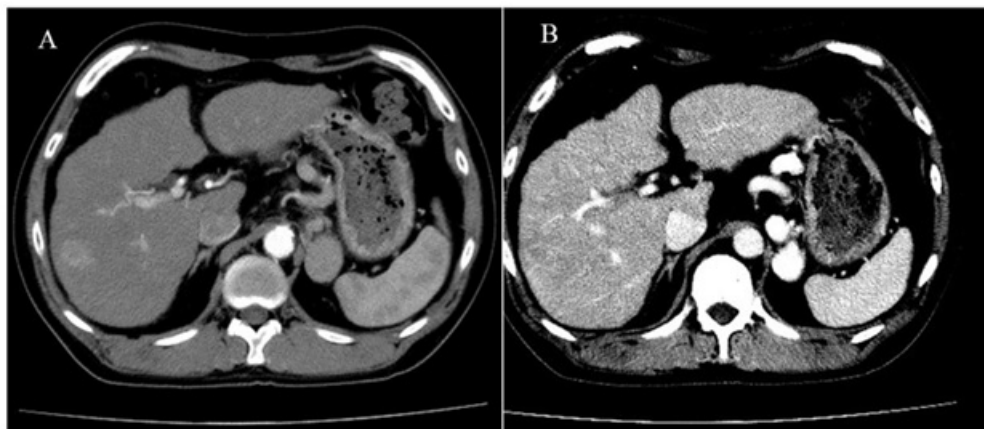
Abdominal computed tomography (CT) showed a hepatic nodule in segment 7 with hyperintensity in the arterial phase (A) and washout in the portal venous phase (B).
